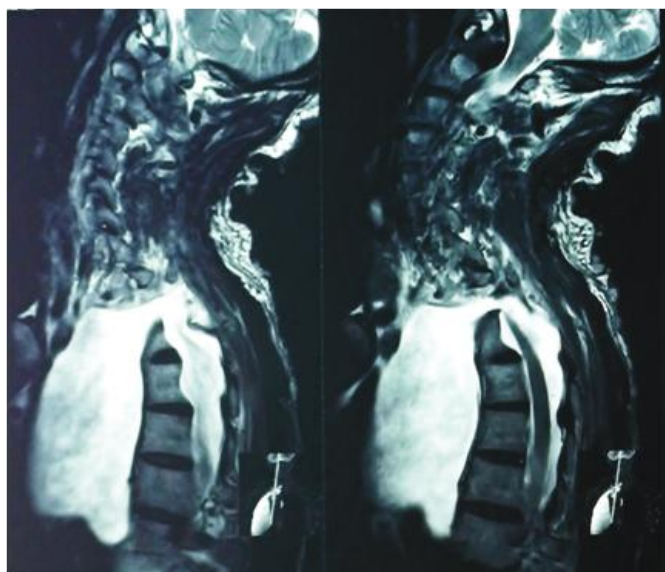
Sagittal T2 MRI showing herniation of cord and CSF filled sac in anterior thoracic region through bony defect
